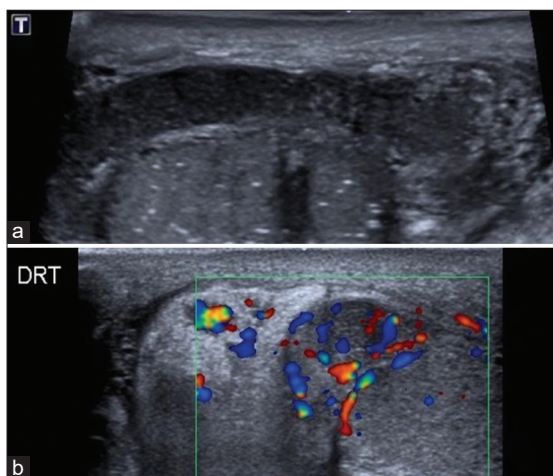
Gray-scale ultrasound of the right epididymis (a), and color Doppler (b) of the right epididymal head and spermatic cord, in the longitudinal plane
